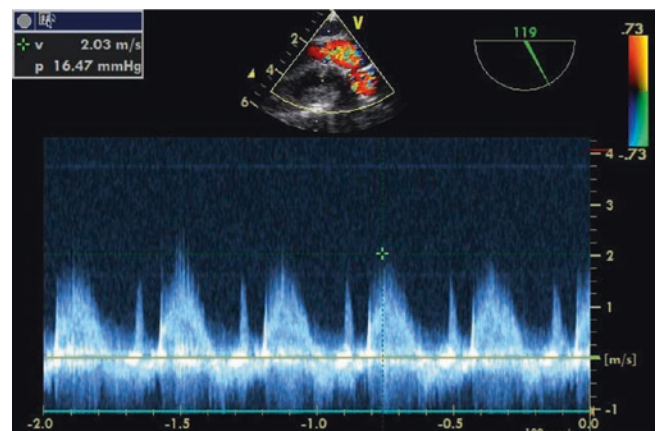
Patient 1: Postoperative transesophageal echocardiography demonstrates the peak systolic aortic valve gradient is about 16.5 mmHg. The ejection fraction increased significantly to 62% immediately
